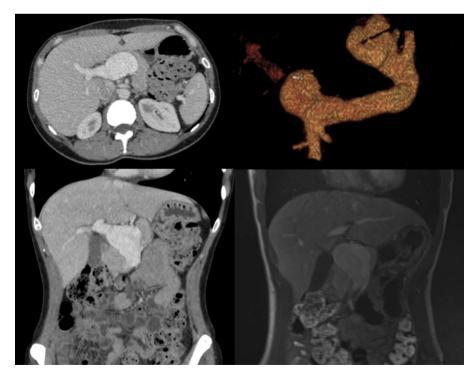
Computed tomography scan of a portal vein an axial view (top left), 3D reconstruction (top right), coronal view on computed tomography scan (bottom left) and on magnetic resonance imaging (bottom right).
